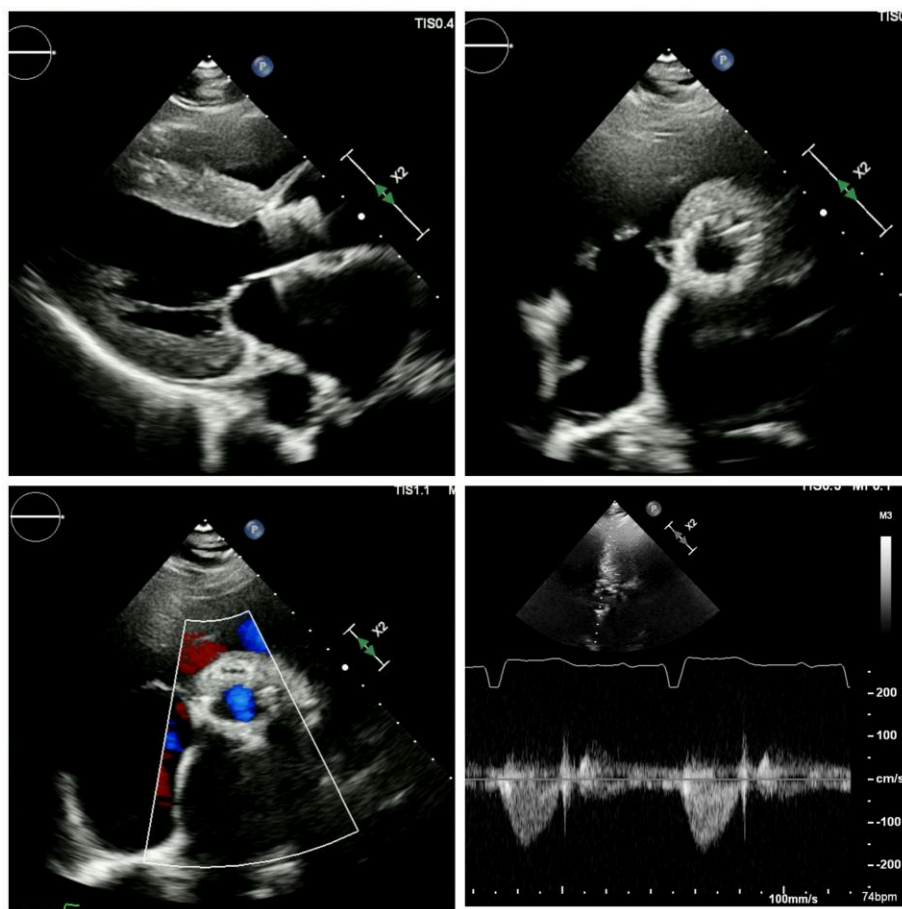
Prosthetic valve implantation (Acurate Neo 2L™). Intraprocedural echocardiographic monitoring confirmed the correct positioning of the valve with no bleeding complications.
